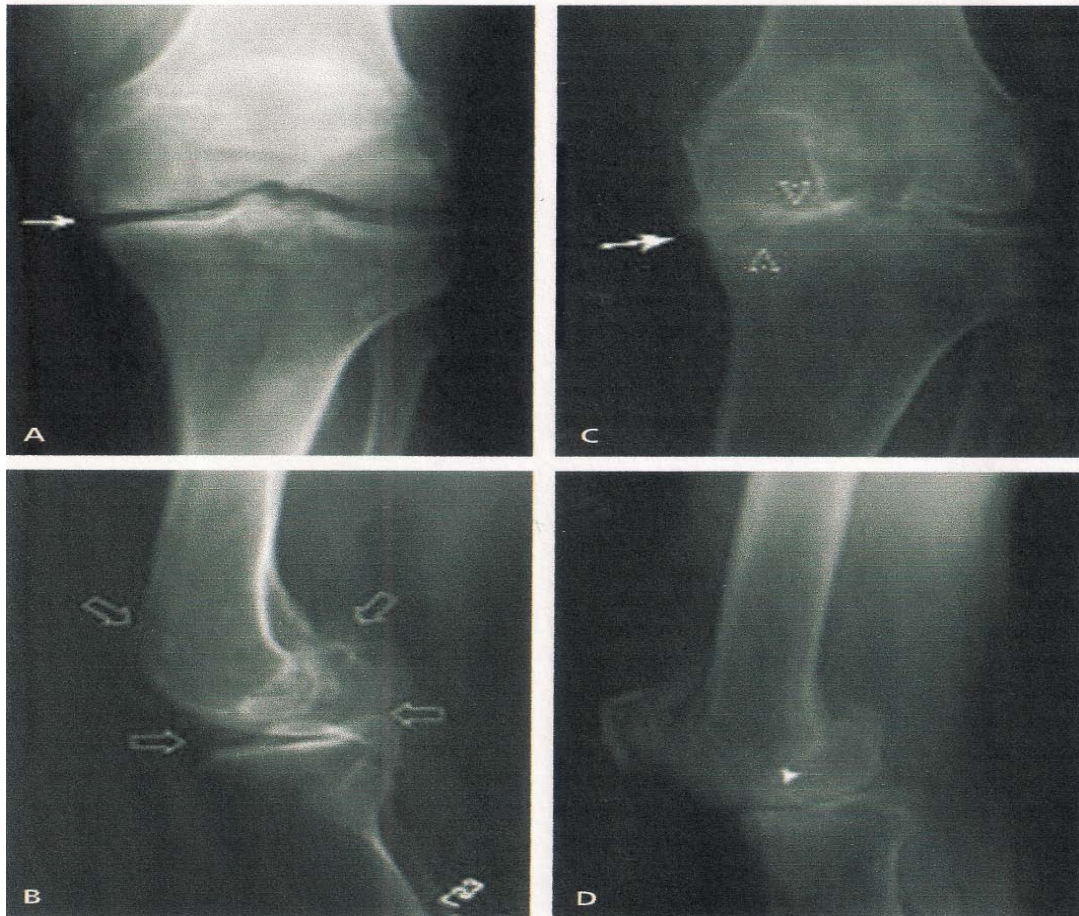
Main radiographic features of KOA. (A) Left knee shows medial joint space narrowing (arrow). (B) Left knee shows sclerosis with marked osteophyte formation (arrows). (C) Osteoarthritic changes with medial joint space narrowing (white arrow) (D) Subchondral cysts (solid arrowhead) (adapted from Swagerty and Hellinger, 2001)
